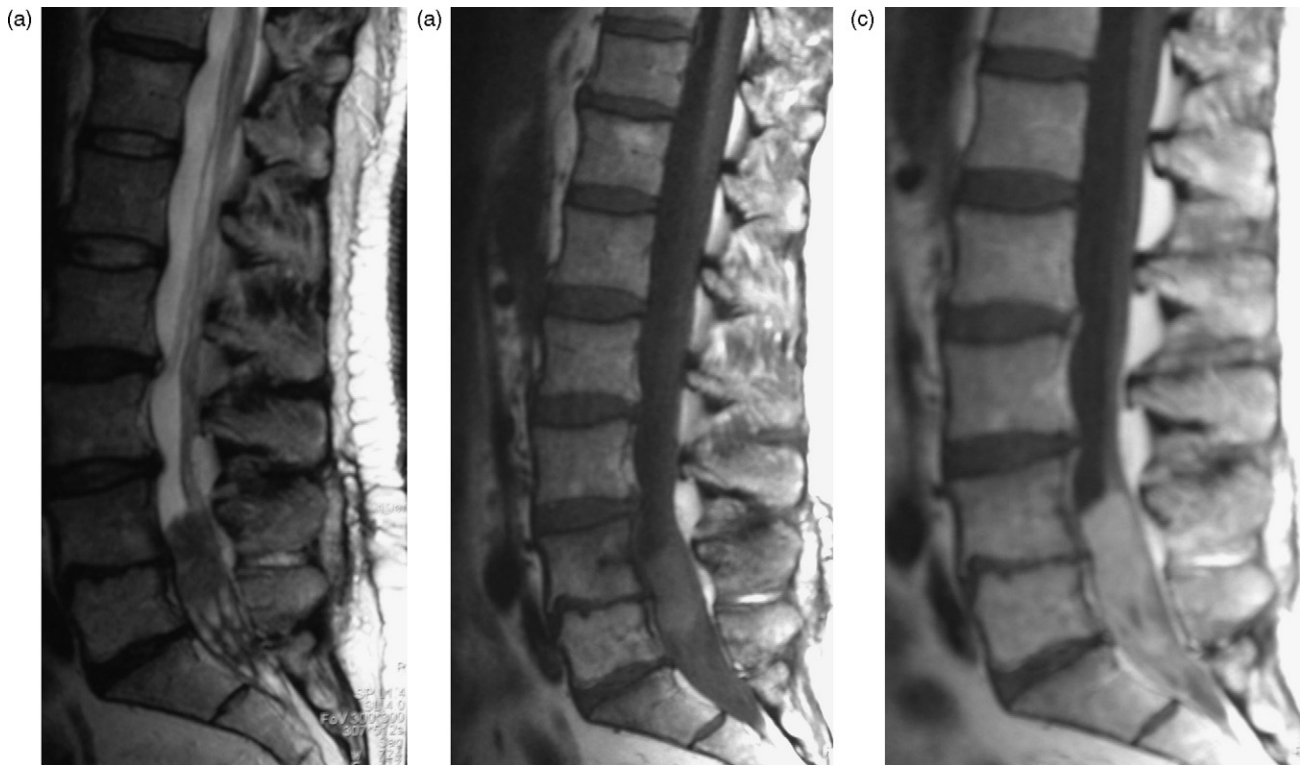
(a) Sagittal T2-weighted MR image in 2004 revealing a soft-tissue mass and thickened root in the thecal sac. (b) and (c) Sagittal T1-weighted MR image 2004 before (b) and after IV gadolinium administration (c): showing the enhancement signal intensity of the intradural mass.
